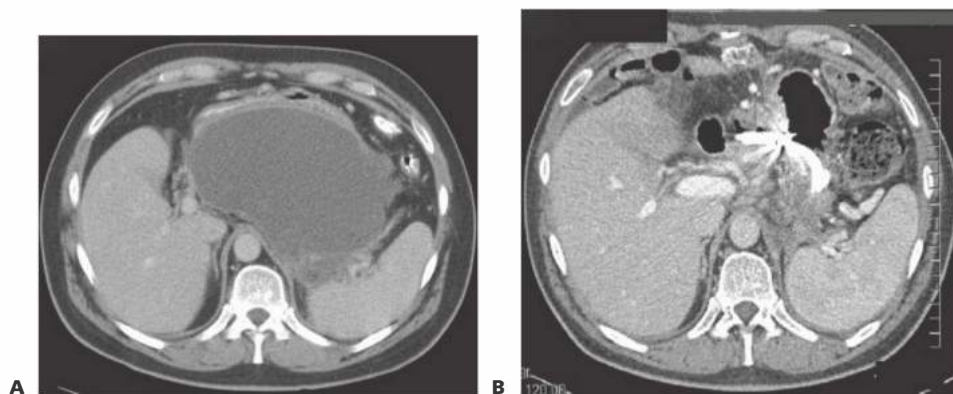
• Ambulatory patient that presented 6 weeks after an episode of necrotizing pancreatitis with symptoms of gastric outlet obstruction. A. CT scan with well-demarcated WON compressing the gastric lumen. B. Five weeks after successful transgastric endoscopic necrosectomy.
